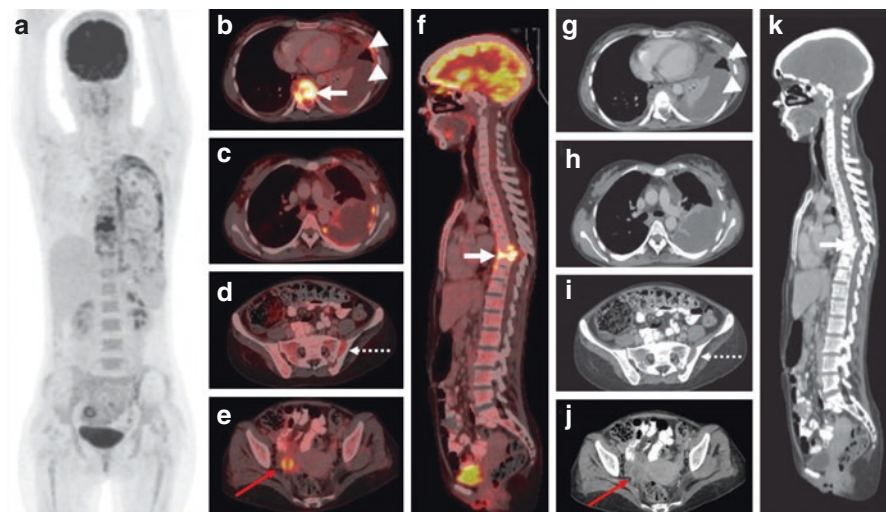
Thirty years old female presented with paraplegia of bilateral lower limbs for one month. MRI spine revealed the collapse of the D7-D9 vertebra with paravertebral soft tissue mass. FNAC from paravertebral soft tissue mass—s/o Tuberculosis. The patient underwent 18F-FDG PET/CT to look at the disease extent. Maximum Projection Image (MIP) (a), PET/CT fused (b, c, d, e, f) and CT only (g, h, i, j, k) images show FDG uptake in FDG lytic lesion with soft tissue component D7–D9 vertebrae with the collapse of the D8 vertebra (arrow b, f, and k). FDG avid left-sided pleural thickening and pleural effusion (b, g, arrowhead). FDG avid lesion with soft tissue component involving the left sacroiliac joint (d, i dashed arrow). Physiological FDG uptake in the right ovary (e, j, red arrow)
